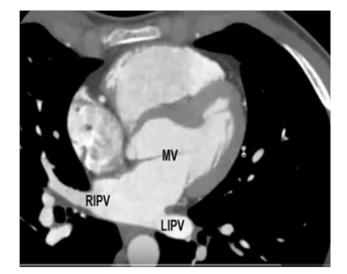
Computed tomography of the heart. The mitral valve is visible between the left atrium and left ventricle. Both inferior pulmonary veins are visible: LIPV and RIPV.
